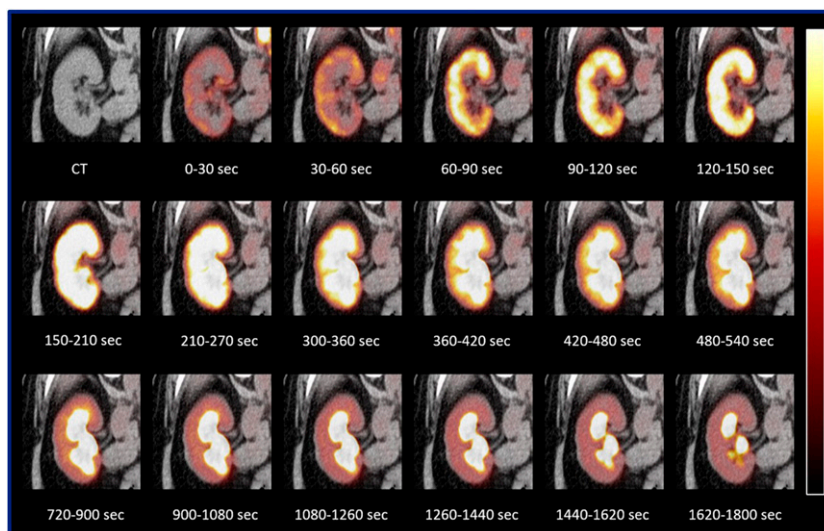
First-in-human ^{18}F -fluorodeoxy-sorbitol PET imaging, showing normal uptake and excretion of the tracer through the urinary system over a time period of 0–30 min after injection. This tracer may provide a more detailed evaluation of renal urodynamics than standard tracers and could facilitate absolute quantitation that is currently not achievable with planar and SPECT renal agents.
